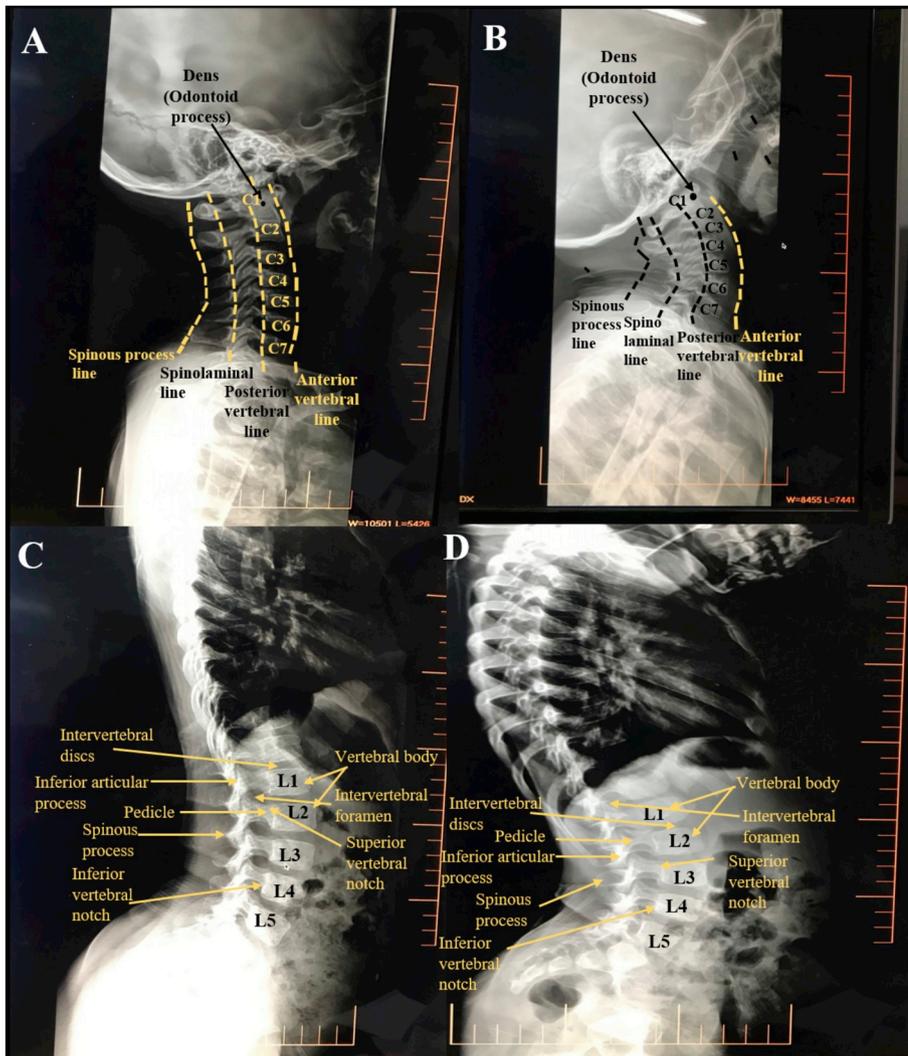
Structural skeleton evaluation of the lateral cervical spine vertebrae and lumbar vertebrae by radiograph imaging in the Schmid Metaphyseal Chondrodysplasia (SMCD)-affected female child and the younger male sibling. A and B, A normal skeleton structure of the seven cervical vertebral spine bodies marked as C1 to C7 with the axially centered dens (odontoid process) structure (marked using black dot), and the unaffected spinous process with the symmetrical spinolaminar, posterior and anterior vertebral lines in the SMCD-affected female child (A) and her younger male sibling (B). C and D, A normal skeleton structure of the five lumbar vertebral bodies marked as L1 to L5 with the unaffected intervertebral disc space; intervertebral foramen; spinous and the inferior articular process in the SMCD-affected female child (C) and the male sibling (D).
